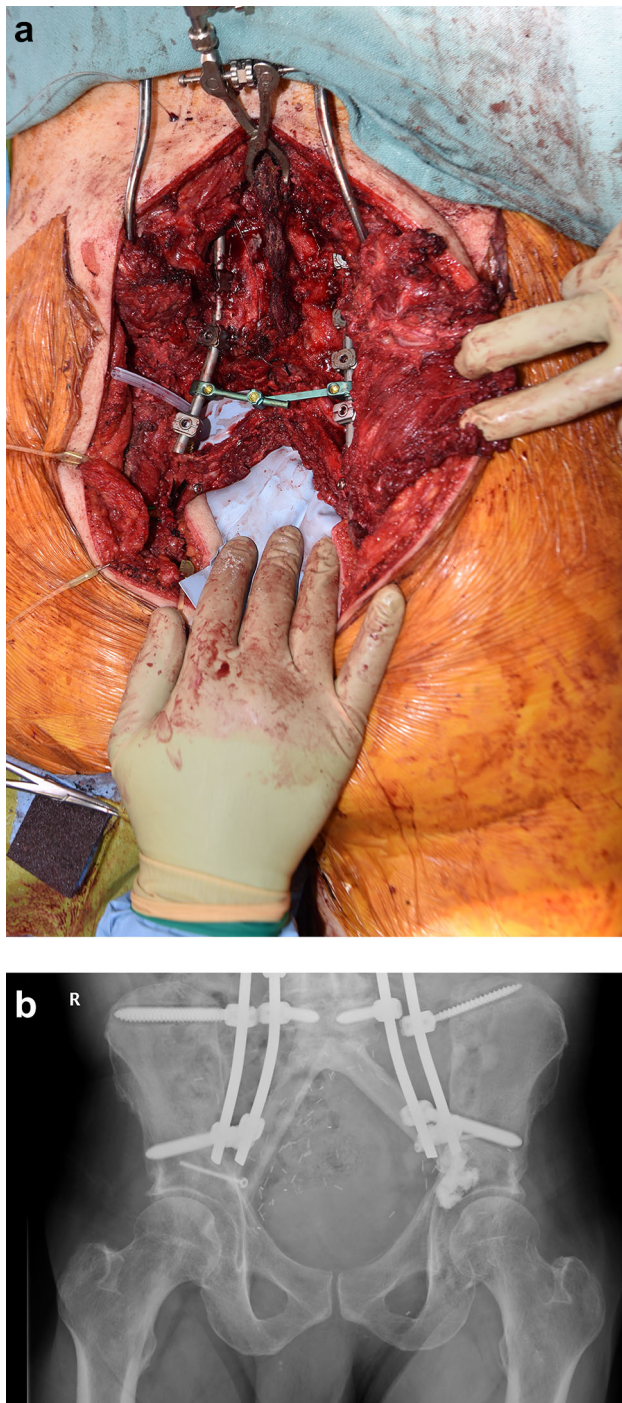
Free fibula flap inset as a double-barrel A-frame strut to reconstruct the anterior column component of the total sacrectomy defect. a In-situ photograph. b Radiograph of the fused fibula 12 months after reconstruction
